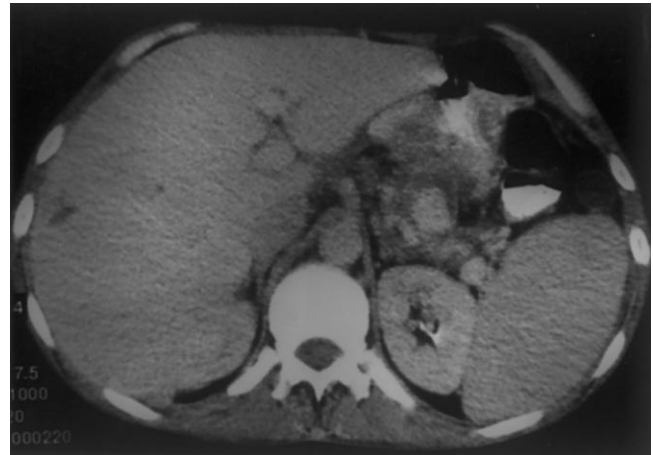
Contrast enhanced CT study. (a) Partially thrombosed splenic artery pseudoaneurysm.
